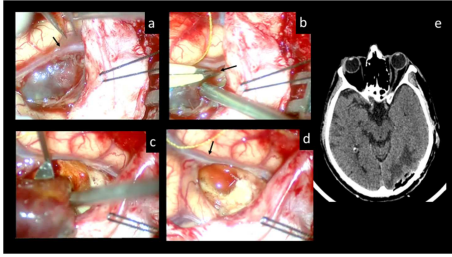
Intraoperative images and post-operative CT scan
